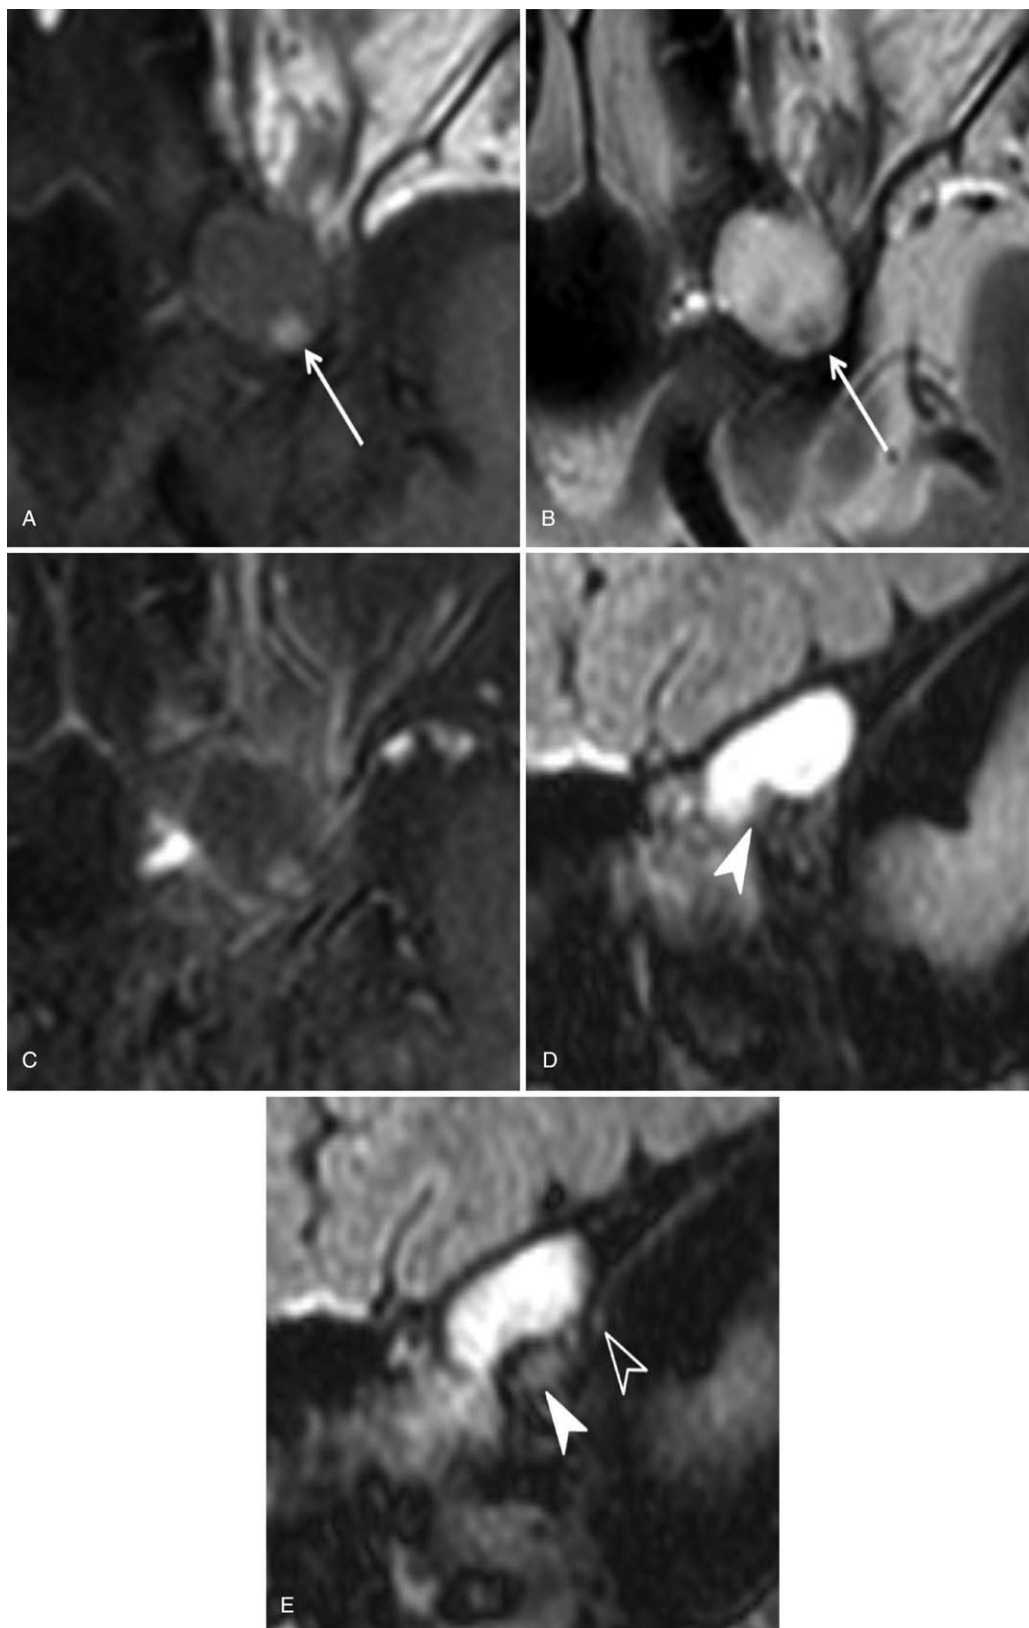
Orbital contrast MRI of the same patient. Axial scans showed predominantly T1 hypointensity (A) and T2 hyperintensity (B) with focal T1 hyperintense and T2 hypointense foci (A and B, arrows). No demonstrable contrast enhancement was observed on the postcontrast T1-weighted image (C). The inferior part of the lesion bulged into the lateral aspect of the optic nerve (D and E, arrowhead) where the left superior ophthalmic vein (E, empty arrowhead) was located.
